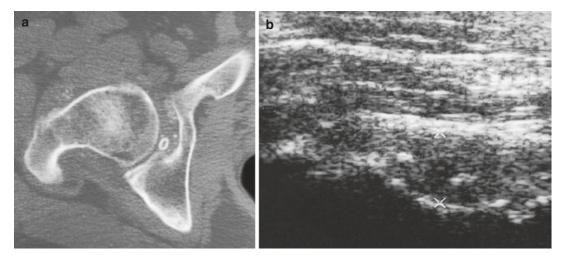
(a, b) Synovial osteochondromatosis of right hip joint in a 40-year-old white man with a 2 year history of right hip pain. (a) Axial CT scan section at tip of greater trochanter; bone window setting. (b) Longitudinal, anterior US image. One, larger, peripherally calcified nodule and numerous small, faintly calcified nodules can be identified, predominantly in the medial and anterior joint space (a) Marked distention of the anterior hip joint space (b) (between calipers). Intra-articular synovial proliferation; two embedded metaplastic nodules. The most proximal, calcified nodule demonstrates posterior acoustic shadowing
